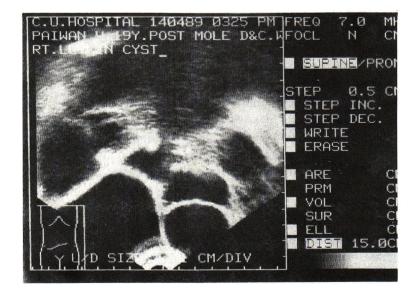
Endovaginal sonography showing right thecalutein cyst.
